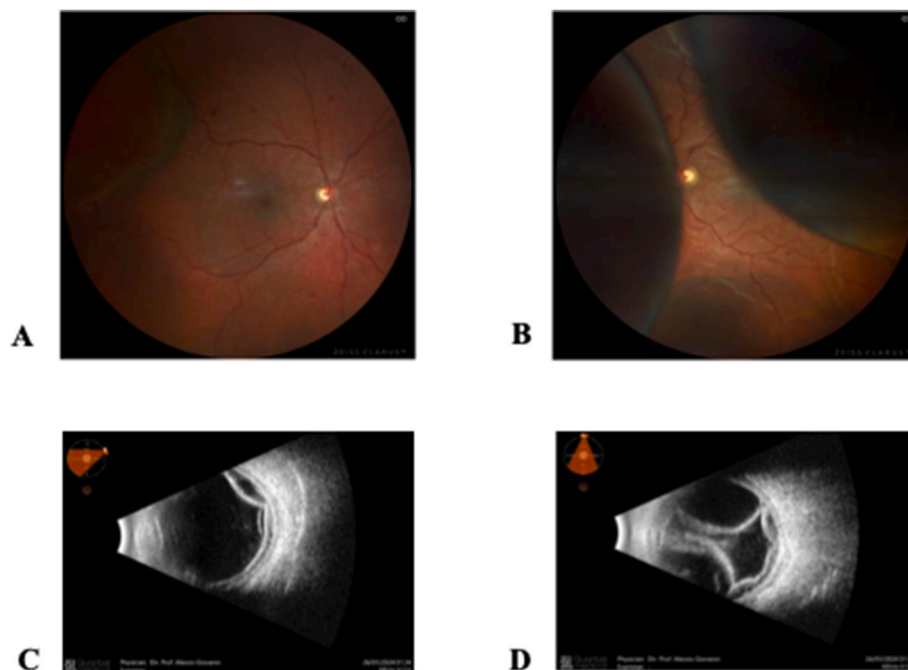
The figure describes in detail the ocular findings at the onset of symptoms. Color fundus photos (A-B) exhibit peripheral temporal choroidal detachment in the right eye (A) and near-kissing choroidal detachments and macular edema in the left eye (B), and in both eyes (A-B) the diffuse intraretinal hemorrhages, mild optic nerve-head pallor, vascular tortuosity, retinal arteriolar narrowing, and arteriovenous nicking, cotton-wool spots. In C-D images, multiple bullous choroidal detachments in both eyes are shown: the majority involving the temporal sector in the right eye (C) and near-kissing choroidal detachments in the left eye (D) through standardized B-scan ultrasound.
